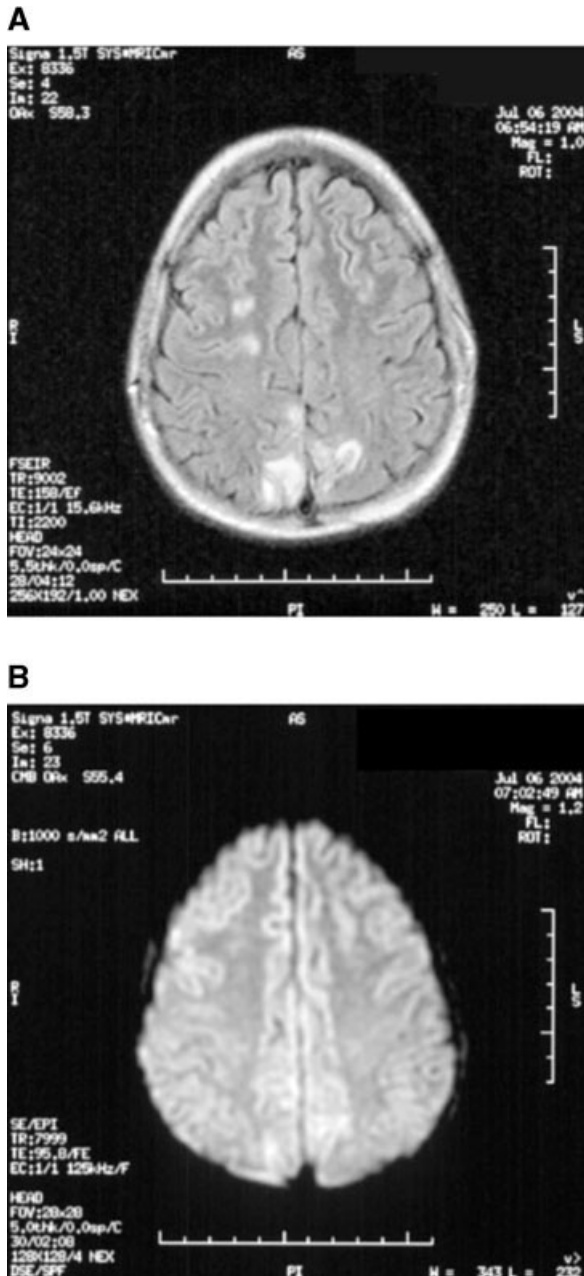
(MRI images): A: Initial T2-weighted FLAIR image demonstrating T2 changes in bilateral frontal and parietal lobes and the right cerebellar hemisphere. B: Initial diffusion weighted image that is normal.
